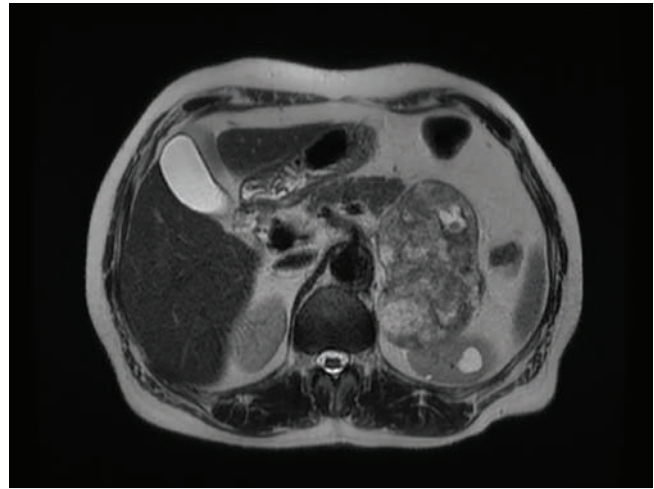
Preoperative MRI image.
